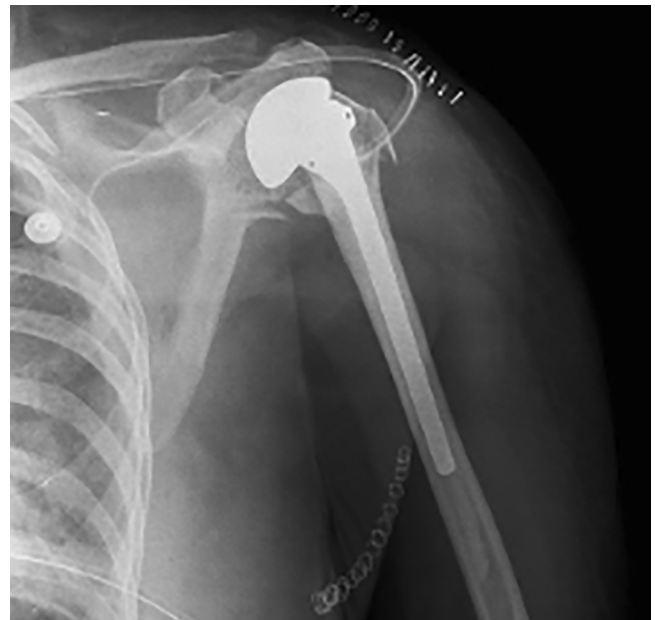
Radiographic study showing the hemiarthroplasty. Note the second rib fracture.
